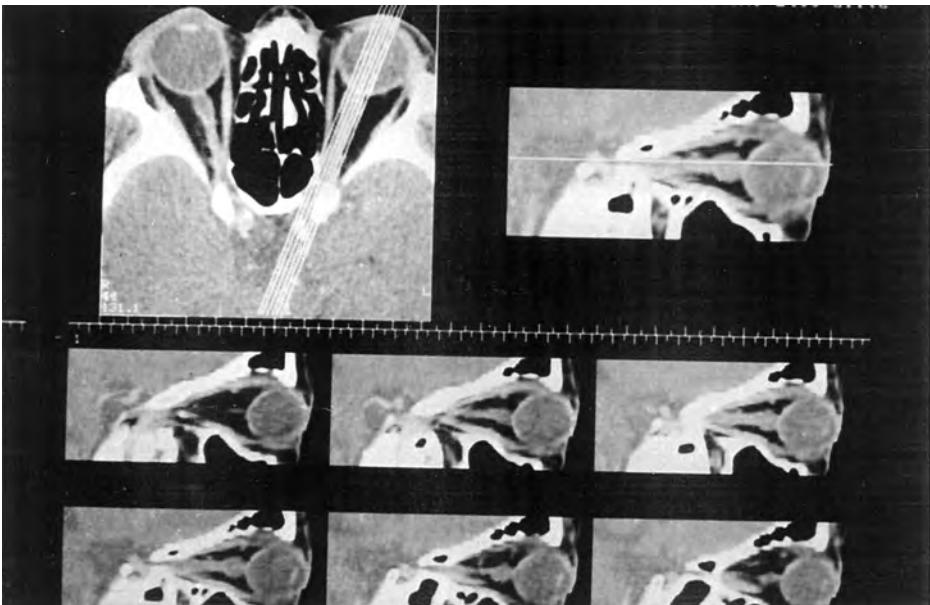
Orbital CT. Thickened, irregular optic sheaths on the left side.
